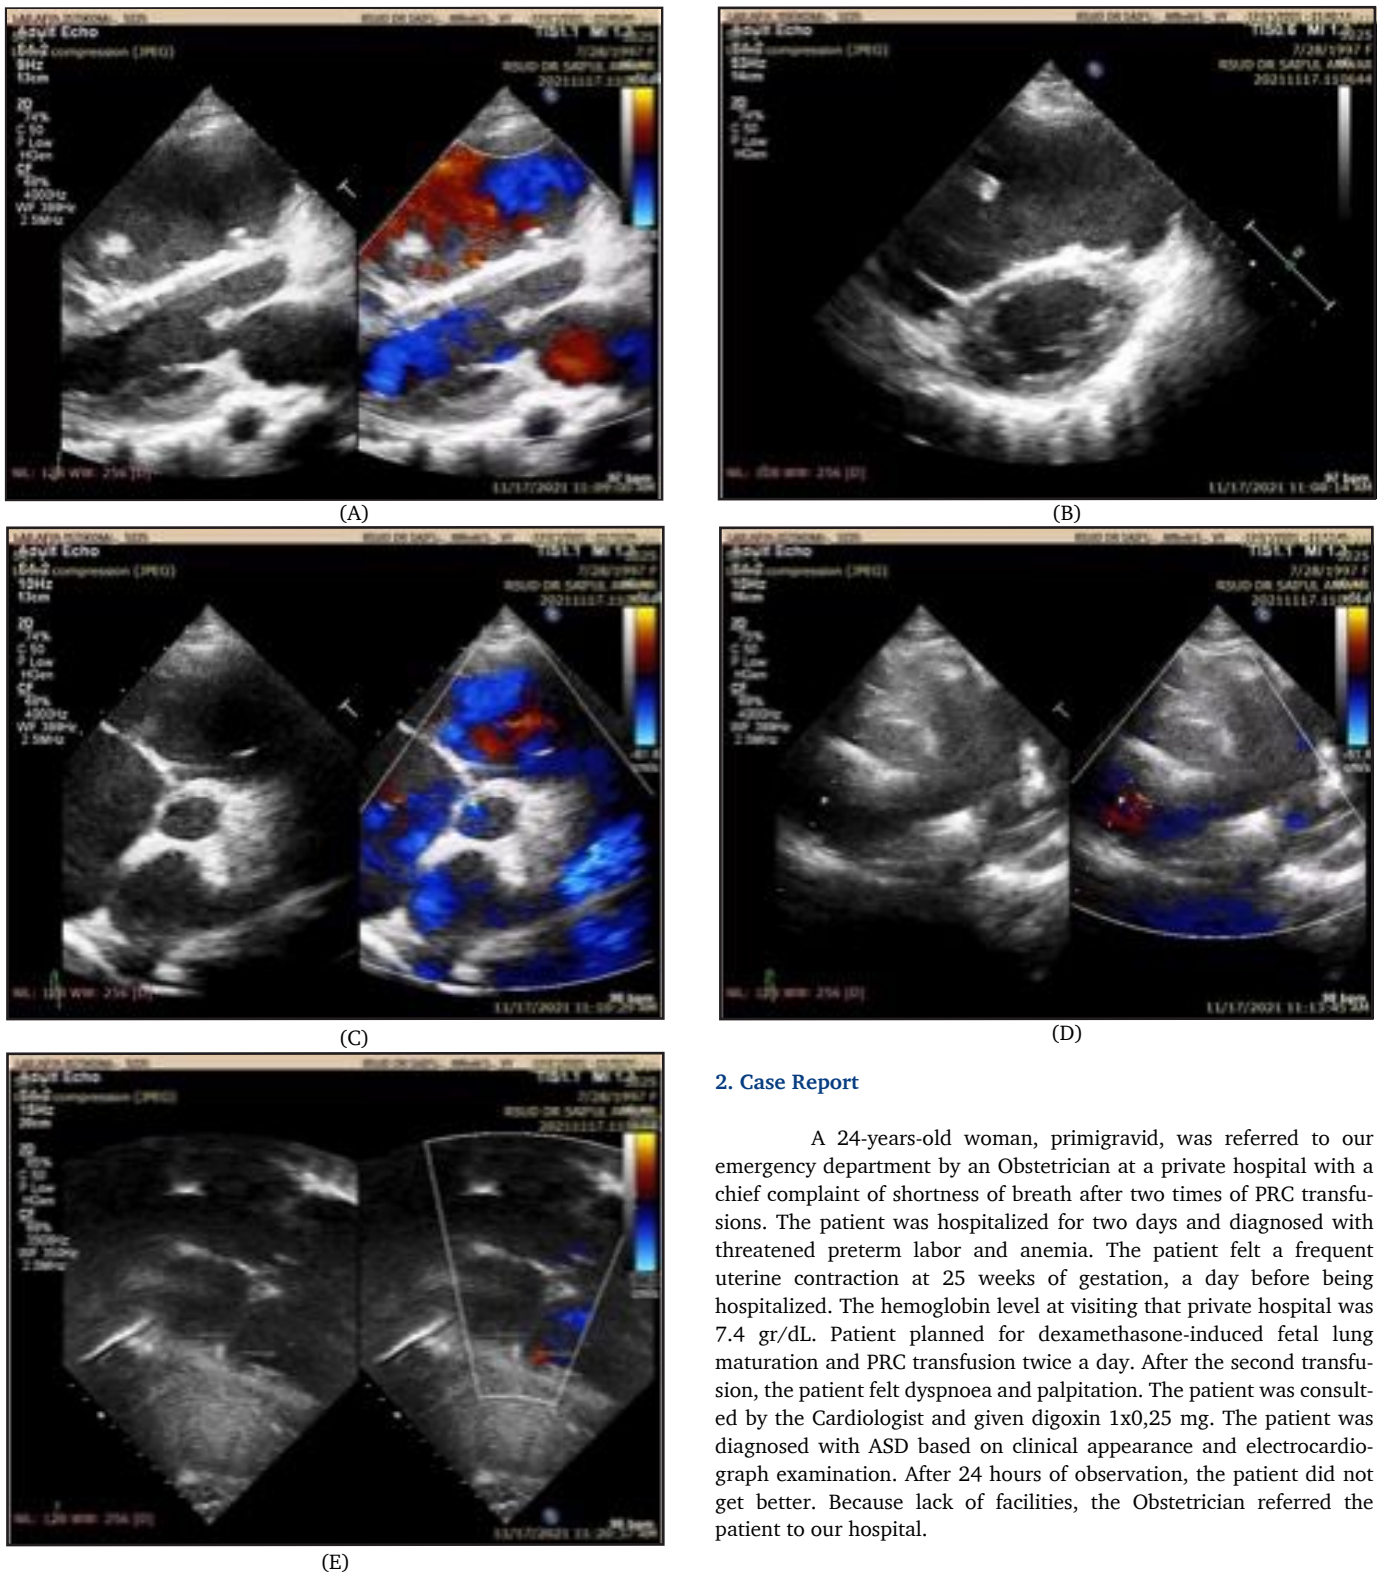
Echocardiographic of idiopathic pulmonary arterial hypertension
